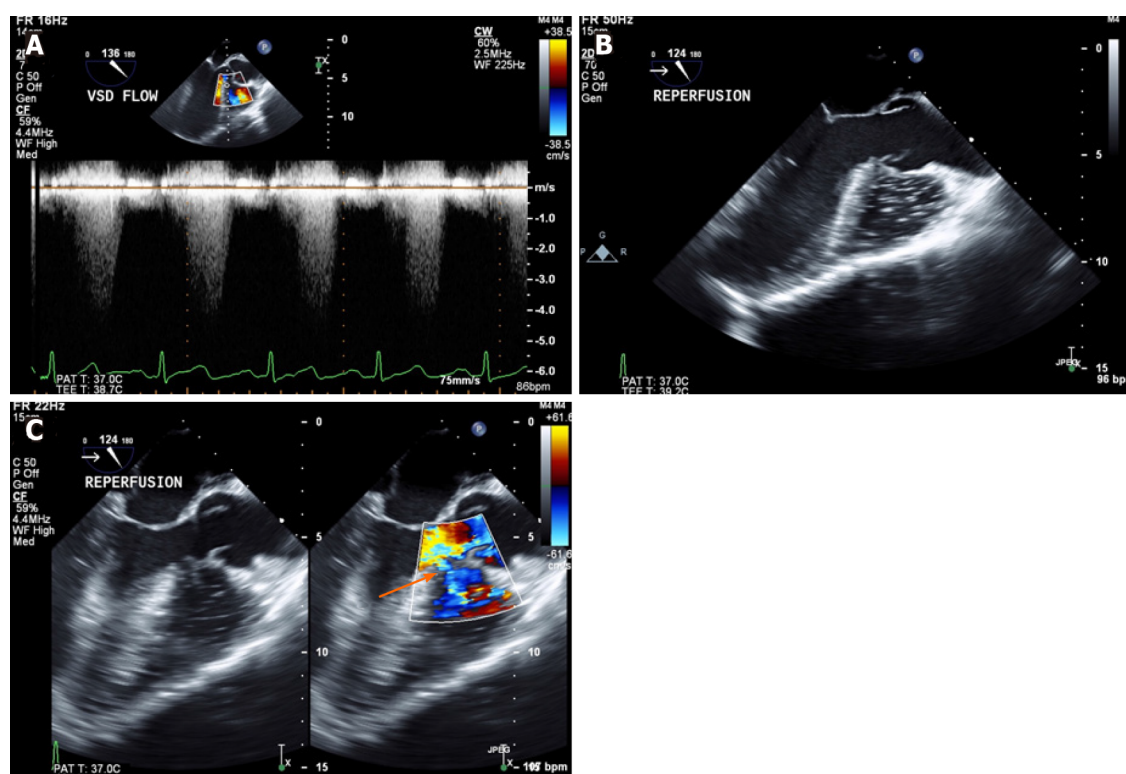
Transesophageal echocardiography mid esophageal long axis view. A: Continuous wave doppler to calculate shunt flow velocity across the ventricular septal defect; B: Air/debris from newly implanted liver in the right ventricle only; C: Unchanged direction of left to right shunt (orange arrow) post reperfusion.
